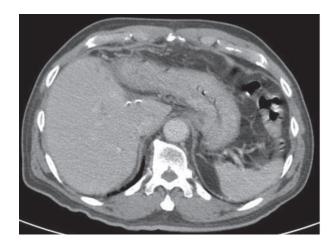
The CT of abdomen with contrast enhancement revealed status post left hepatectomy, No evidence of tumor recurrence at surgical margin is observed.
